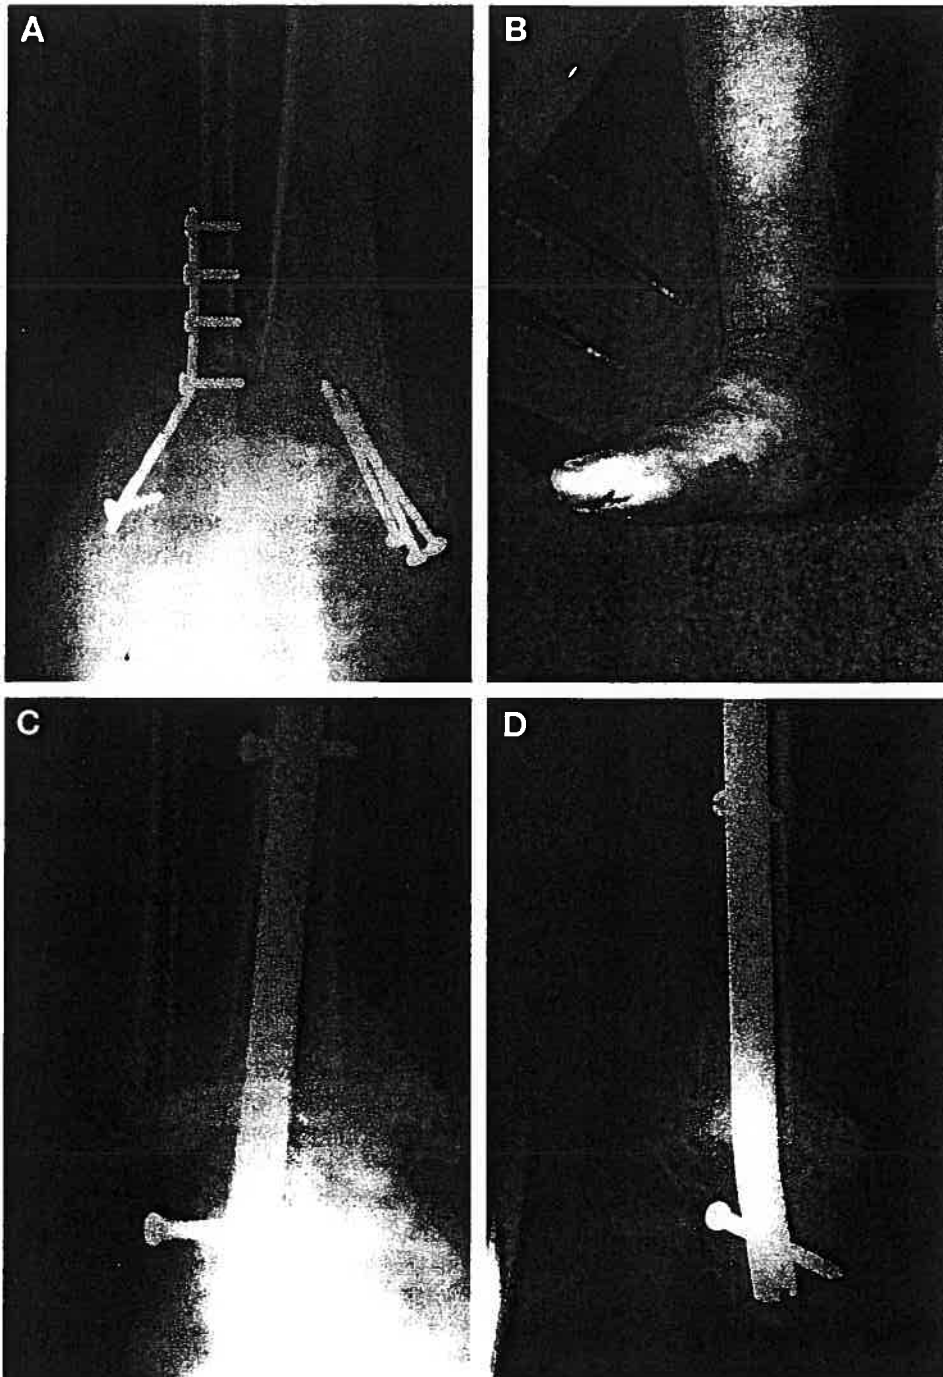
Sixty-three-year-old, insulin-dependent, 95-kg, type-II diabetic. *A*, Radiograph at presentation after open reduction of simple ankle fracture. *B*, Wagner grade 0 foot. *C*, *D*, radiographs 6 months after ankle fusion.
